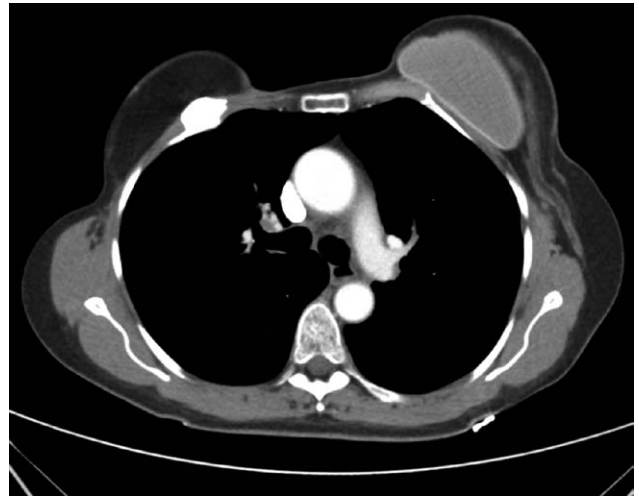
Computed tomography demonstrating a bone-forming lesion at the anterior end of the third rib.
